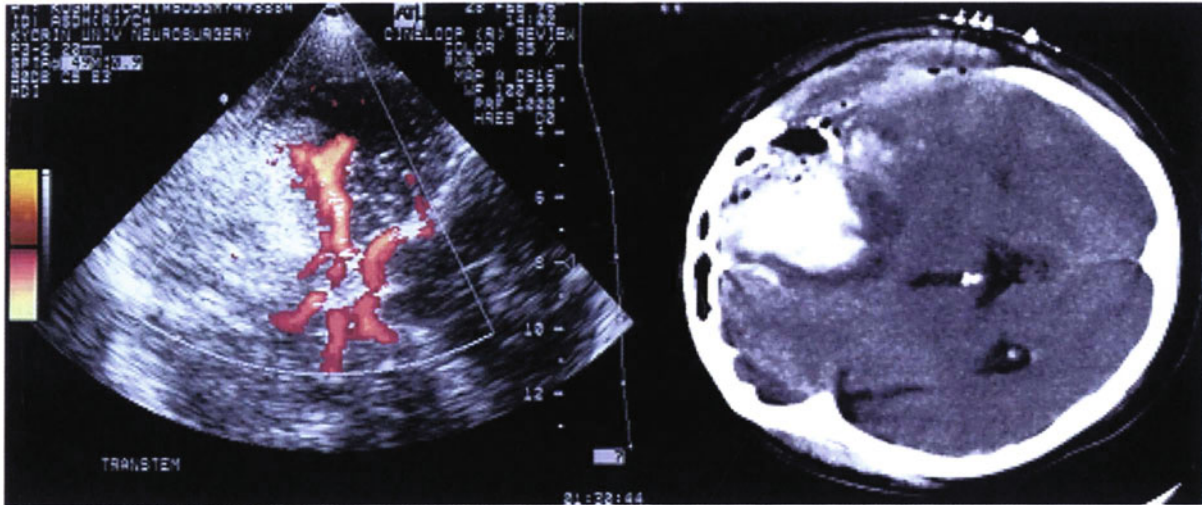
Fifty five-year-old patient with right acute subdural hematoma is postoperatively examined three days after injury. Hyper-echoic lesion in right frontal lobe shown by PDI (left) corresponds with CT scan (right). PDI visualizes shifted anterior cerebral arteries
